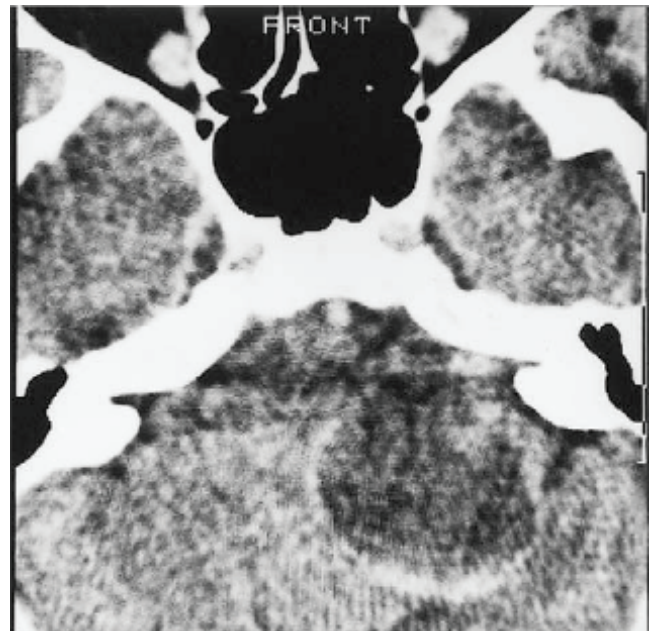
A large cystic tumour with a large hypodense area on CT scan.
